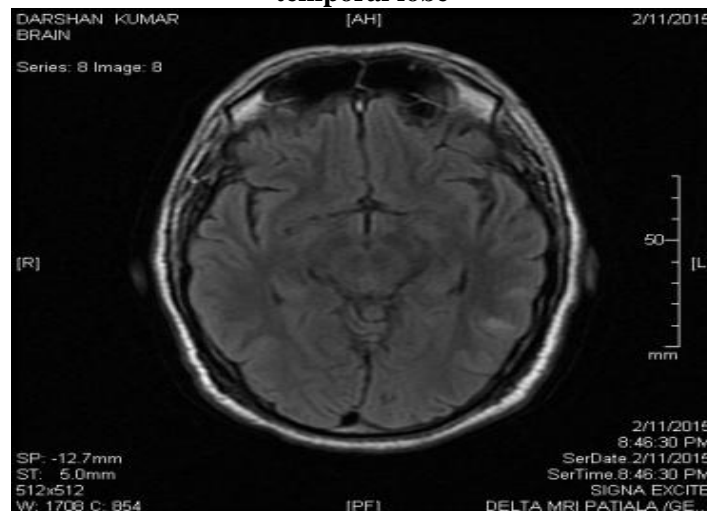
3MRI Brain- increased axial FLAIR signal in ponsFigure: 4MRI Brain- increased coronal FLAIR signal in left frontal lobeFigure: 5MRI Brain- increased axial FLAIR signal in left temporal lobe
